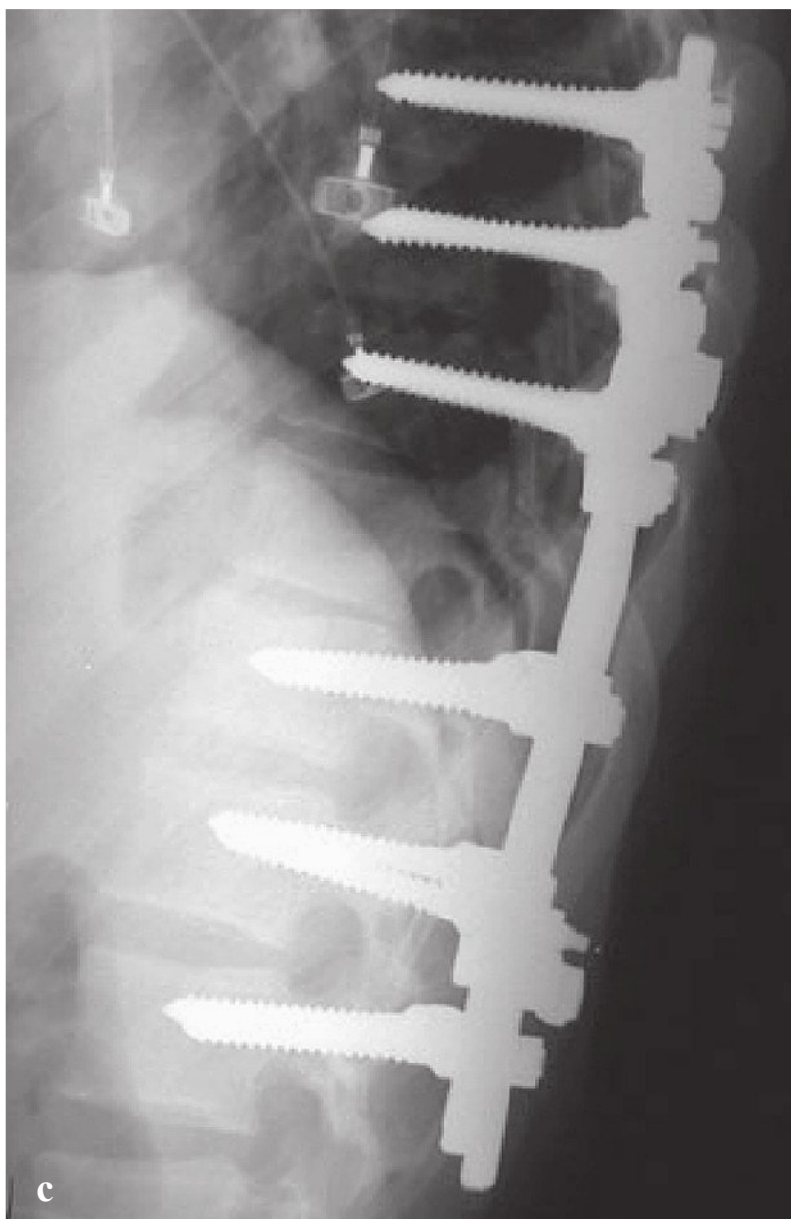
(a) A sagittal computed tomographic reconstruction of a fracture-dislocation of the thoracolumbar spine demonstrating marked vertebral body displacement and canal narrowing. (b) Sagittal magnetic resonance imaging of the thoracolumbar spine of the same patient demonstrating marked canal narrowing. Note the draping of the spinal cord over the posterosuperior edge of the caudal thoracic vertebrae. (c) A postoperative lateral radiograph of the same patient demonstrating reduction of the spinal deformity followed by a fusion and stabilization with segmental pedicle screw anchors spanning three levels above and below the level of injury.
